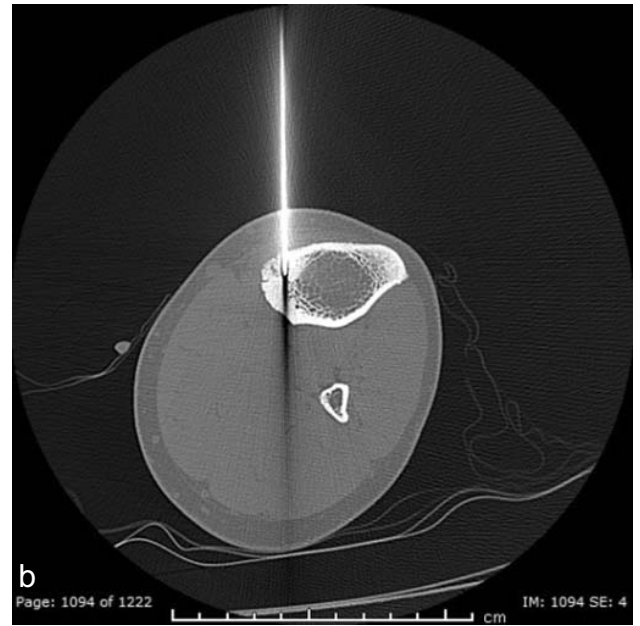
(a,b): Axial CT images bone window showing MWA guide-wire introduced inside the nidus in cortex of tibial shaft.
